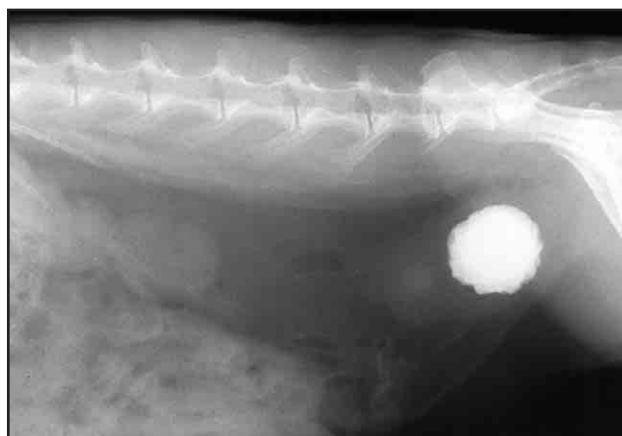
Cystic calculi can be extremely large due to the continuous deposition of calcium around the initial small urolith. The thickness of the urinary bladder is visible in this radiograph as an increased radiodensity.
